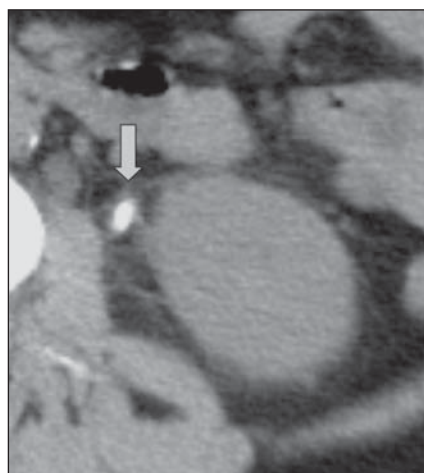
Perirenal fat heterogeneity. Non-contrast-enhanced helical CT axial slices. The perirenal fat that typically is homogeneously hypodense, in this case presents an increased density due the presence of numberless septa related to a calculus obstructing the upper ureter (arrow).
